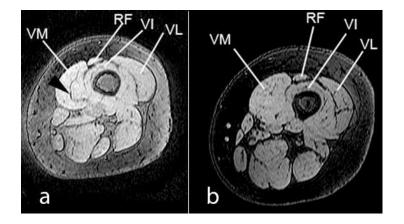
Axial MRI of left thigh; a) arrowhead indicates plane of separation between VMO (superficial) and VML (deep); b) control subject, no plane of separation visible in VM at the corresponding axial level. RF rectus femoris, VI vastus intermedius, VL vastus lateralis, VM vastus medialis (from Benjafield et al., 2014)
